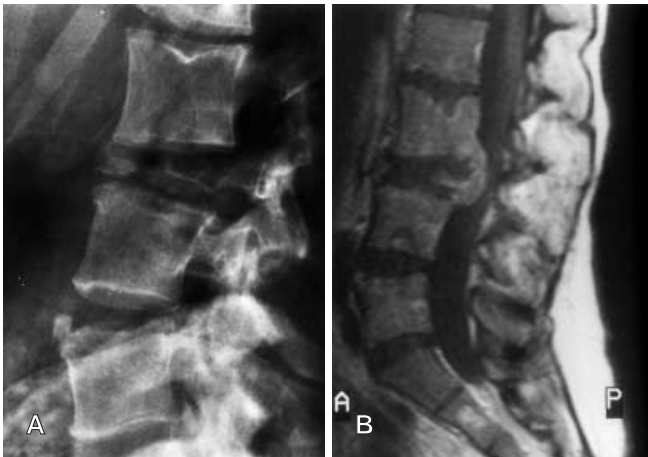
A 36-year-old woman (patient 5) with L3 vertebral body collapse due to a breast cancer metastasis and mild paraparesis. A Lateral view conventional radiograph displays a vertebra plana resulting in a kyphotic deformity. B T1-weighted sagittal magnetic resonance (MR) image reveals a compression of the cauda equina
